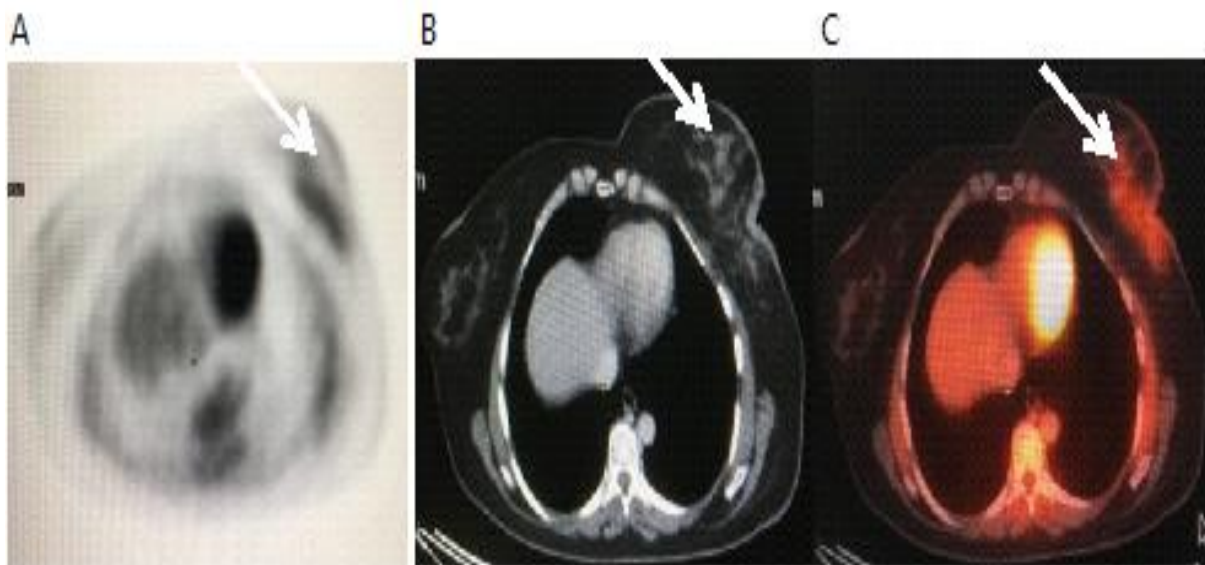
A case of left breast cancer showed local disease recurrence. PET-CT image showed hyper metabolic FDG avid lesion at the left breast, while the CECT images is indeterminate.
